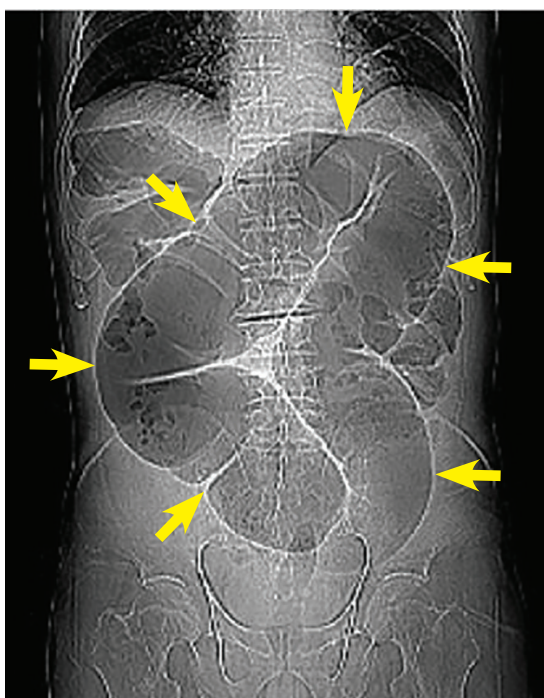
Computed tomography preliminary view showed a distended sigmoid loop with an inverted U-shape (arrows), also known as the coffee bean sign.
